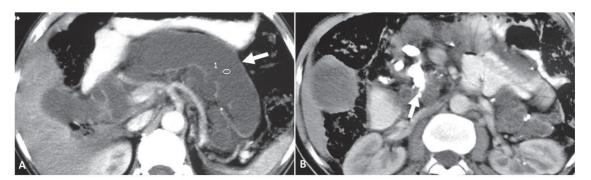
A 25-year-old male patient with tropical chronic pancreatitis (TCP) and diabetes mellitus. Axial images (A, B) of contrast CT shows completely atrophic pancreas (not visualized), hugely dilated main pancreatic duct (A, arrow) and large intraductal calculi in the head region of the pancreas (B, arrow). Note absence of calculi in the body and tail region.
